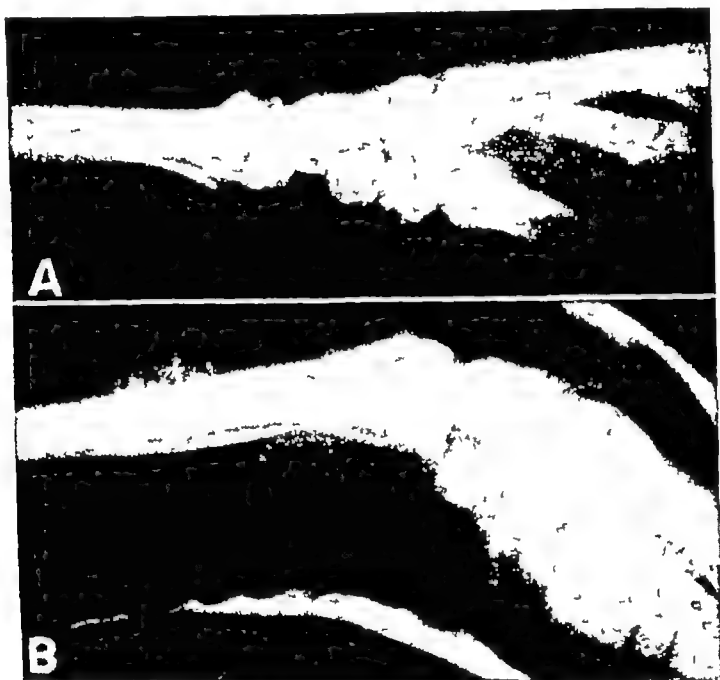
A*, simple Colles' fracture, *B*, following proper reduction. This fracture may be overlooked without x-rays.
